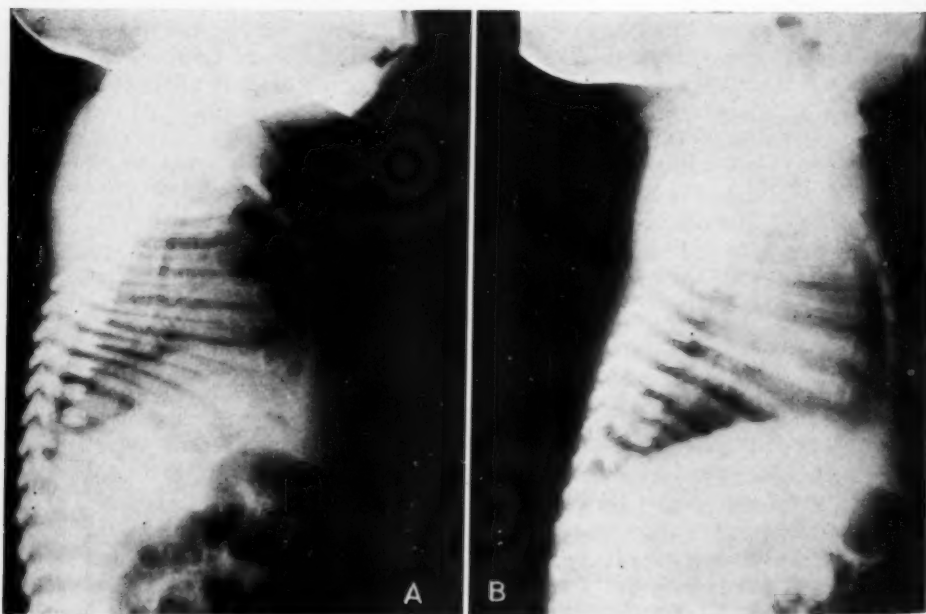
Case 2: A. Three days after the roentgenograms shown in Fig. 3 were made the air in the mediastinum is seen to be decreased in amount. B. One month after birth there is no evidence of mediastinal air.
